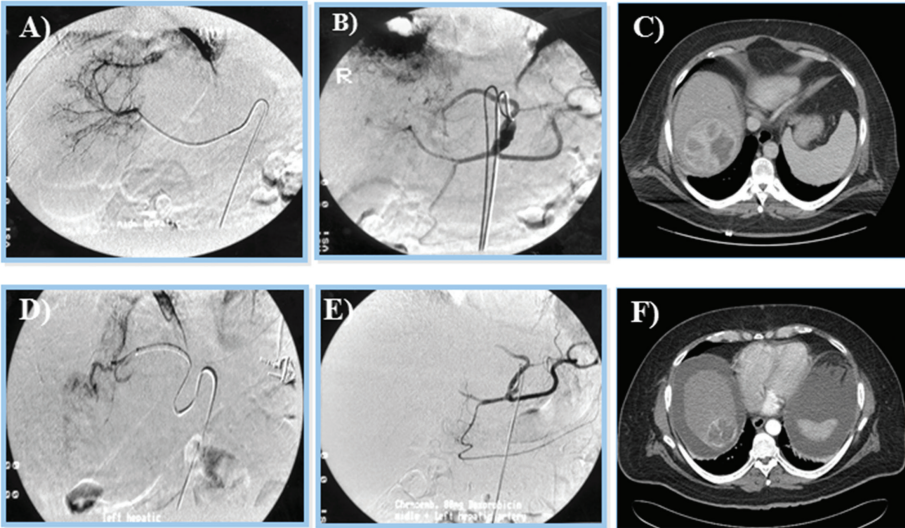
Trans-arterial chemoembolization of the liver for hepatocellular carcinoma. A and B. Selective arterial embolization of the vessels feeding the tumor in the liver. C. Tumor visualized by CT scan. The procedure is performed with or without chemotherapy. D and E. After embolization, angiography showed obliteration of feeding vessels with shrinkage of the tumor. F. Follow up CT scan after embolization. Note an increase in patient's ascites.
